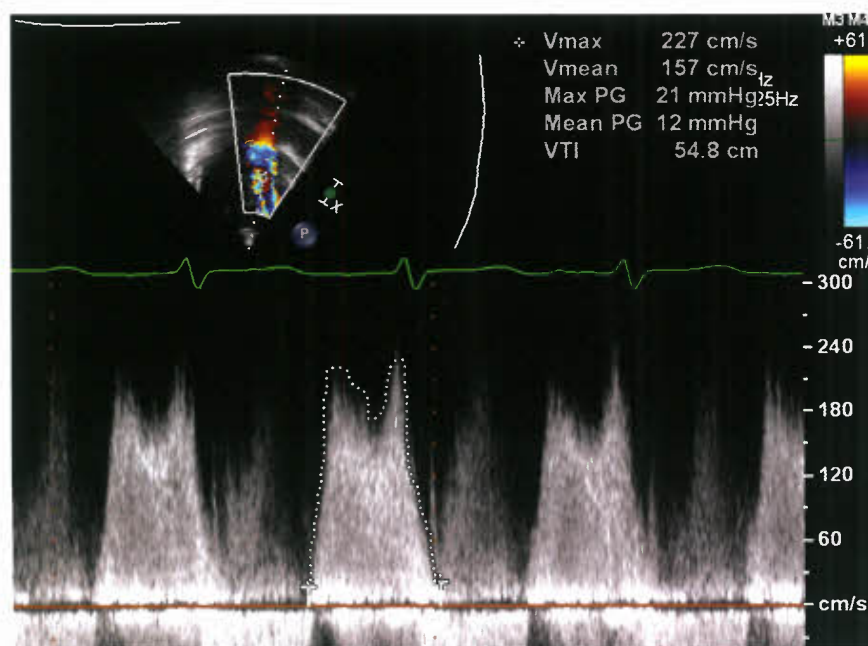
Mitral stenosis. Continuous wave Doppler signal through the inflow in the LV. The mean gradient across the valve is calculated.
